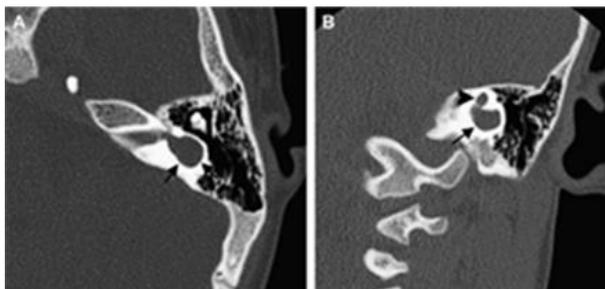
Common cavity malformations showed axial section (a), and coronal section CT scan of right temporal showing incomplete structures of the vestibule, cochlea and semicircular canal (b)
